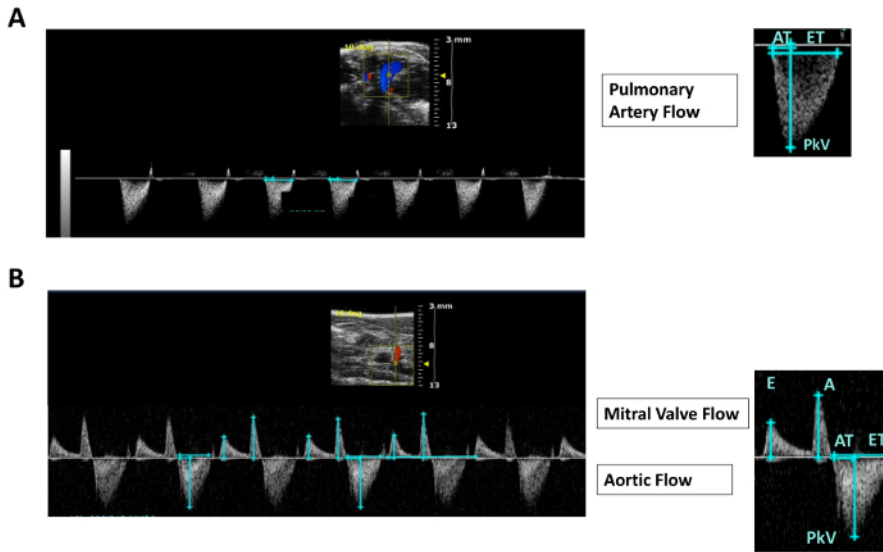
Pulsed Wave Doppler Tracing of Fetal Pulmonary, Aortic and Mitral Flow Indices. (A) Representative image of pulmonary artery pulsed wave Doppler tracing (left). Quantification methods (lines) of pulmonary flow indices PKV (peak velocity), AT (acceleration time), ET (ejection time) are shown (right) from the longitudinal four-chamber view. (B) Representative image of mitral and aortic pulsed Doppler flow pattern (left) and quantification of mitral valve flow indices E (early diastolic velocity) and A (atrial contraction), and aortic flow indices AT, ET, and PKV (right) are shown from the four-chamber imaging plane. [Please click here to view a larger version of this figure.](#)
